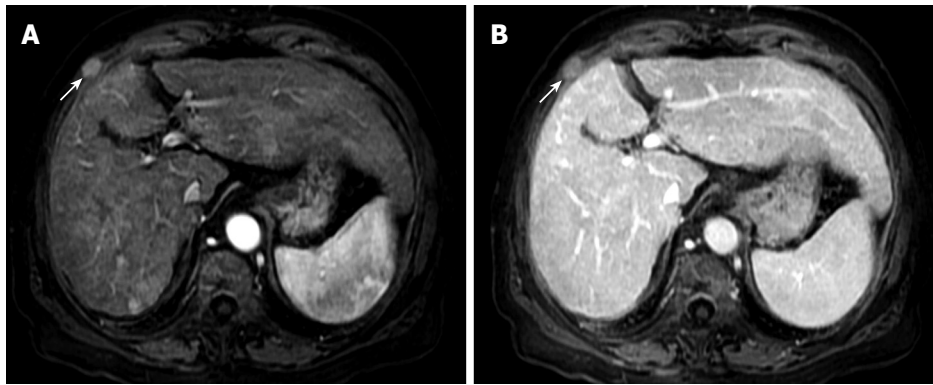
MRI features of HCC seeding following RFA. A: An arterial phase MRI examination of the liver and an enhancing mass in the intercostal space, indicated by the arrowheads, in the right hemithorax; B: A delayed phase MRI examination that shows the mass in the intercostal space, but this is hypointense compared with the rest of the liver.
